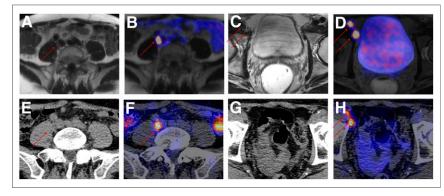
Preoperative ⁶⁸Ga-HBED-CC PSMA PET/MR (A–D) and ^{99m}Tc-PSMA-I&S SPECT/CT (E–H). ⁶⁸Ga-HBED-CC PSMA PET/MR shows iliac (A and B) and inguinal lymph node metastases (C and D). ^{99m}Tc-PSMA-I&S SPECT/CT at 12 h after injection reveals intense tracer uptake in same lymph nodes.
